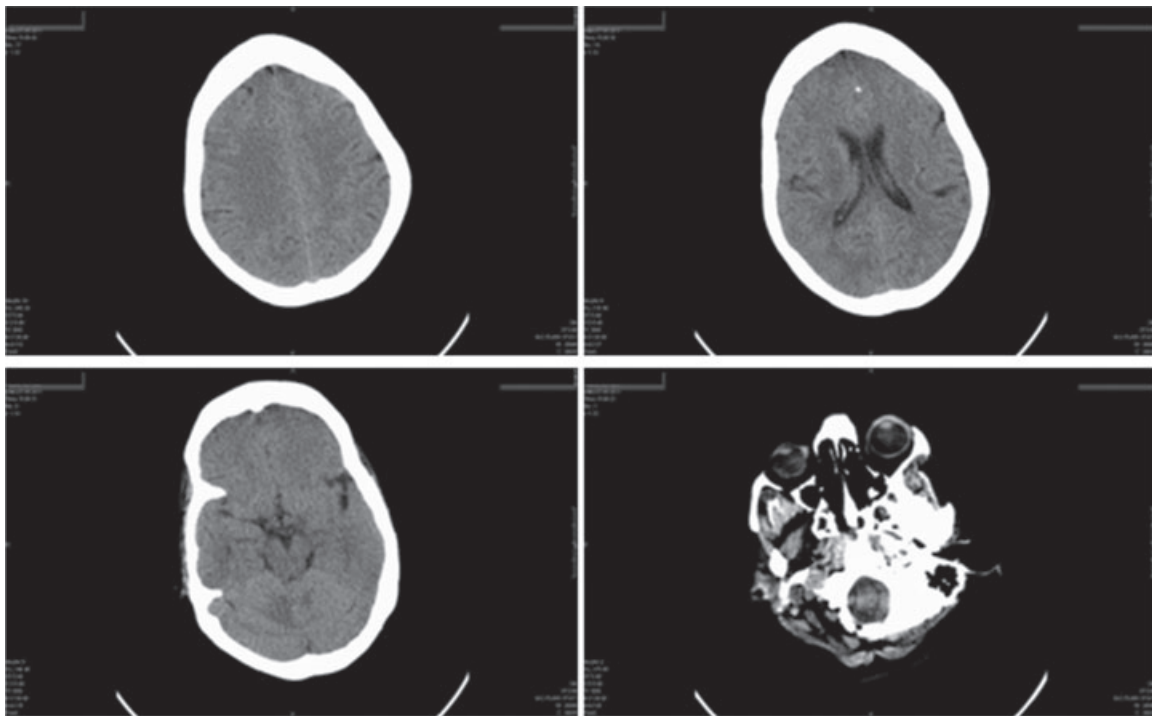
CT of the brain shows non-specific changes of diffuse oedema, manifested by sulcal effacement (top left) and a loss of subarachnoid space around the mid-brain (bottom left). There is a calcified lesion in the left medial frontal lobe suggestive of an old cysticercal lesion – a probable explanation of the seizures in the past (top right). Proptosis is also evident in the scan (bottom right).
